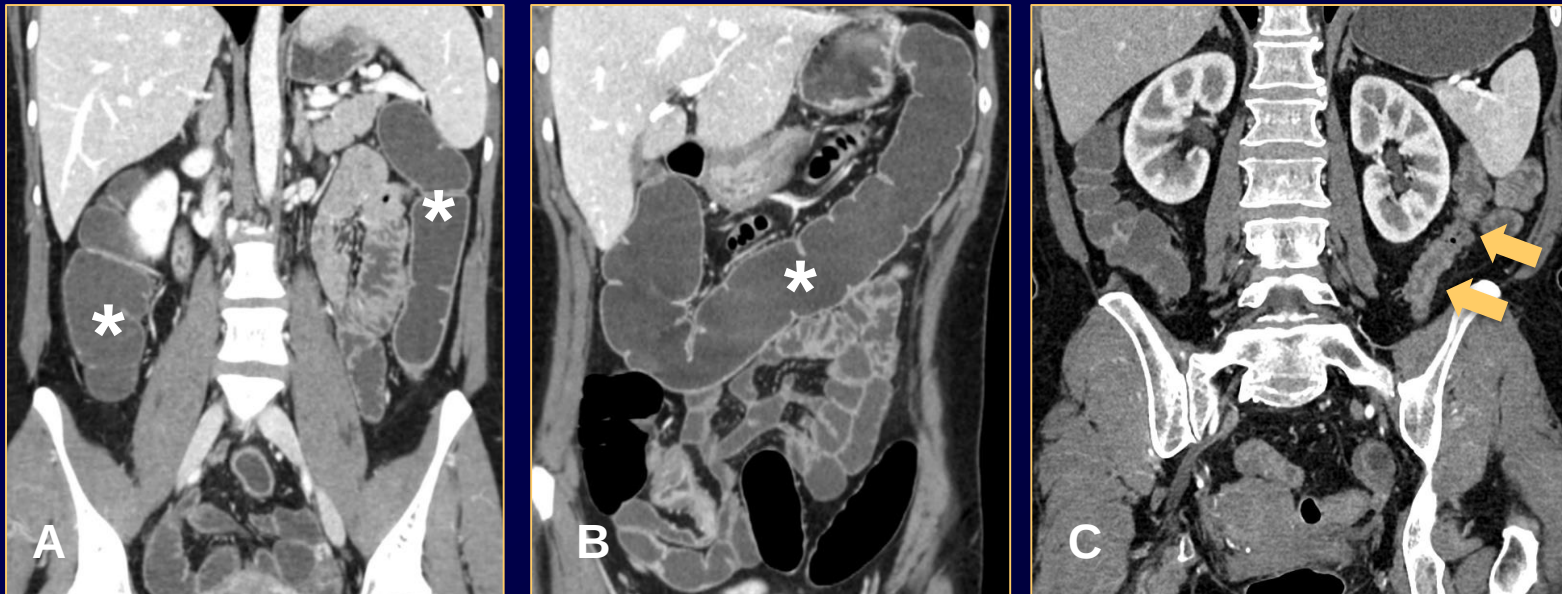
ECT-WE (A, B) shows a good distension of the colon (asterisks); incomplete distension of the colon is evident in this patient studied with PEG-CT (C), especially of the left colon (arrows).
